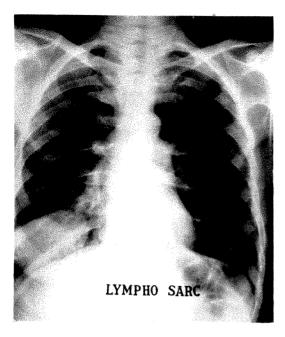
Roentgenogram showing large discrete-in-repulmonary nodule in lymphosarcoma.
